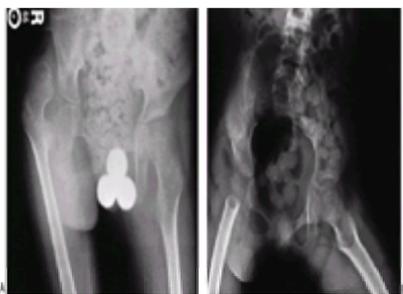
This nonambulatory child's painful dislocated right hip was treated by resection of the proximal femur just distal to the lesser trochanter and oversewing muscle flaps. This is known as the Castle procedure. His pain was relieved. A: Preoperative anteroposterior radiograph shows the dislocated right hip with femoral head deformity and acetabular dysplasia. B: Postoperative radiograph. The proximal femur has been resected at the distal end of the lesser trochanter.
